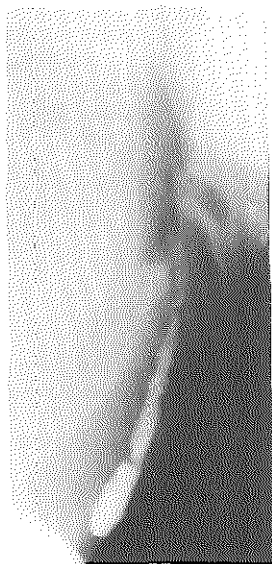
Lateral X-ray view of the neck. Fistulogram depicting a branchiogenic fistulous tract from the level of the thyroid gland to the tonsillar fossa cranially.
